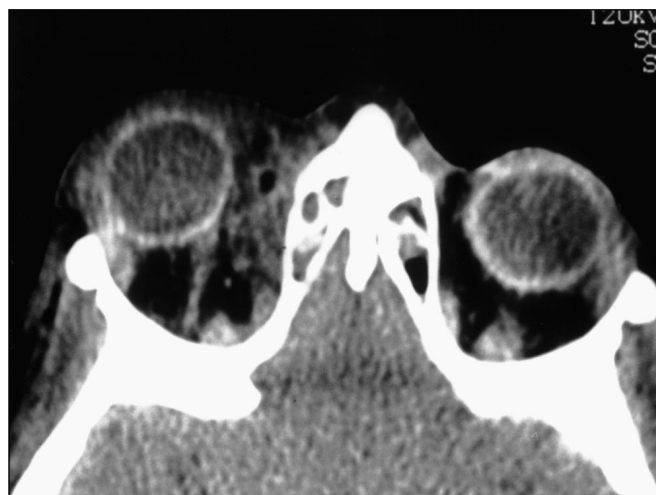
CT scan examination of the second patient, showing an infiltrating mass in the medial part of the orbit and the eyelids.
